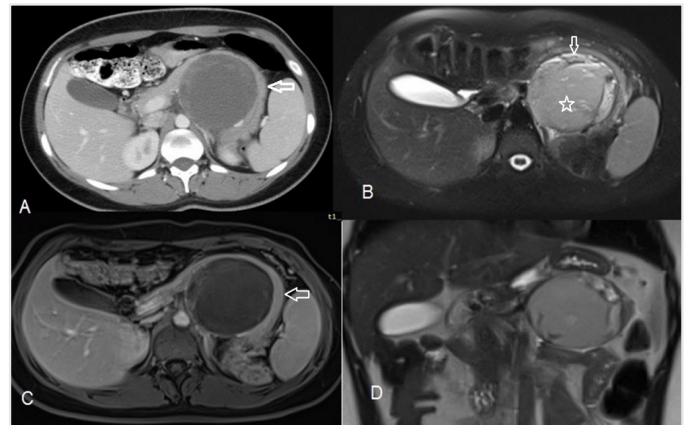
A) A well-circumscribed mass lesion located at the posterior aspect of the body and tail of the pancreas (arrow). No contrast enhancement at the anterior and medial walls of the cystic mass. B) Axial T2-weighted image showing a mass lesion with hypointense fluid signal within the center (star), layering debris, and mild early enhancement on the wall and septae (arrow). C) Axial T1-weighted image did not show contrast enhancement on the solid components of the mass (arrow). D) Coronal T2-weighted image
